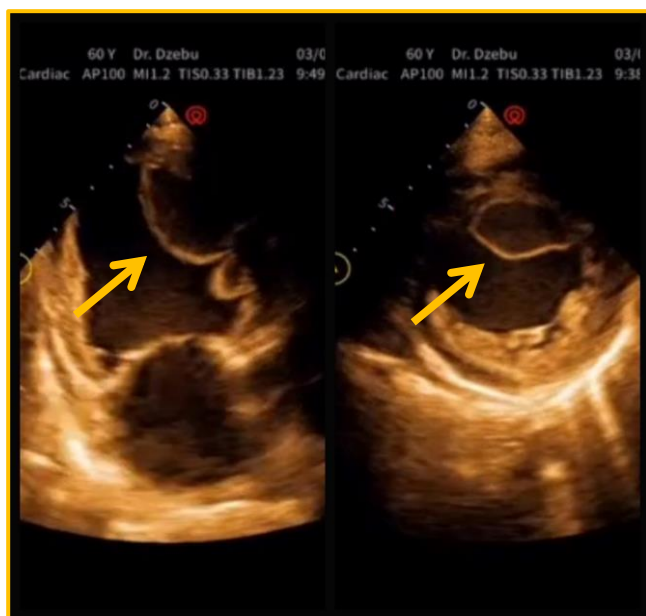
Echocardiogram performed at patient admission (arrow: thrombus)
